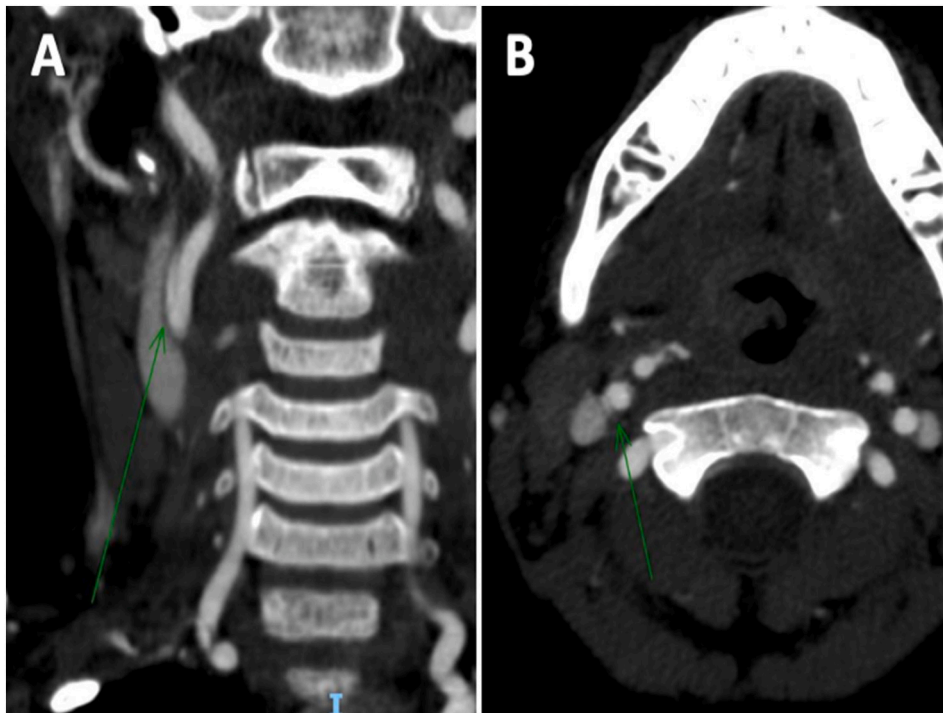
CT Angiogram on presentation demonstrating ICA dissection (green arrow) in coronal (A) and axial (B) views. (For interpretation of the references to colour in this figure legend, the reader is referred to the web version of this article.)
